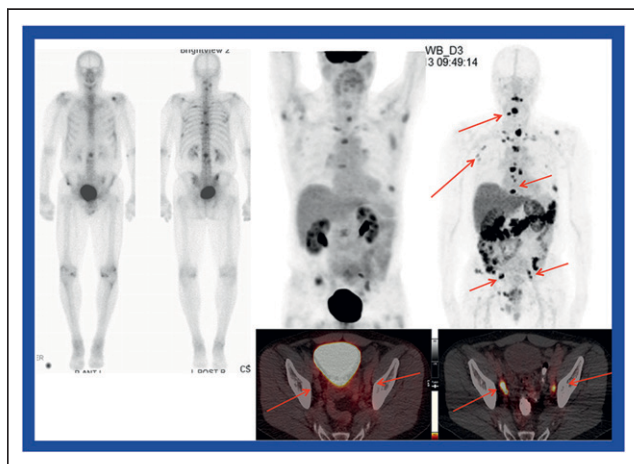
$^{177}\text{Lu}$ -labeled DOTAGA-PSMA small molecule therapy in metastasized castrate-resistant prostate cancer. Left block: Pre- (left) and post- (right) therapy imaging. Right block: Pre- (left) and post- (right) therapy PET imaging shows molecular complete remission.
